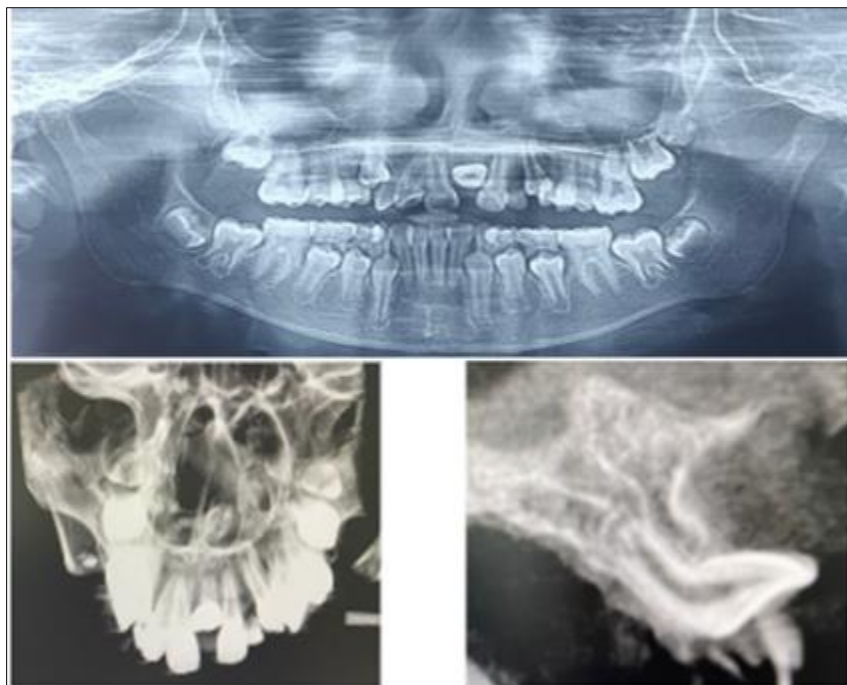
Radiographs panoramic at initial (a). Radiographs CBCT view showing impacted tooth #21(b)
